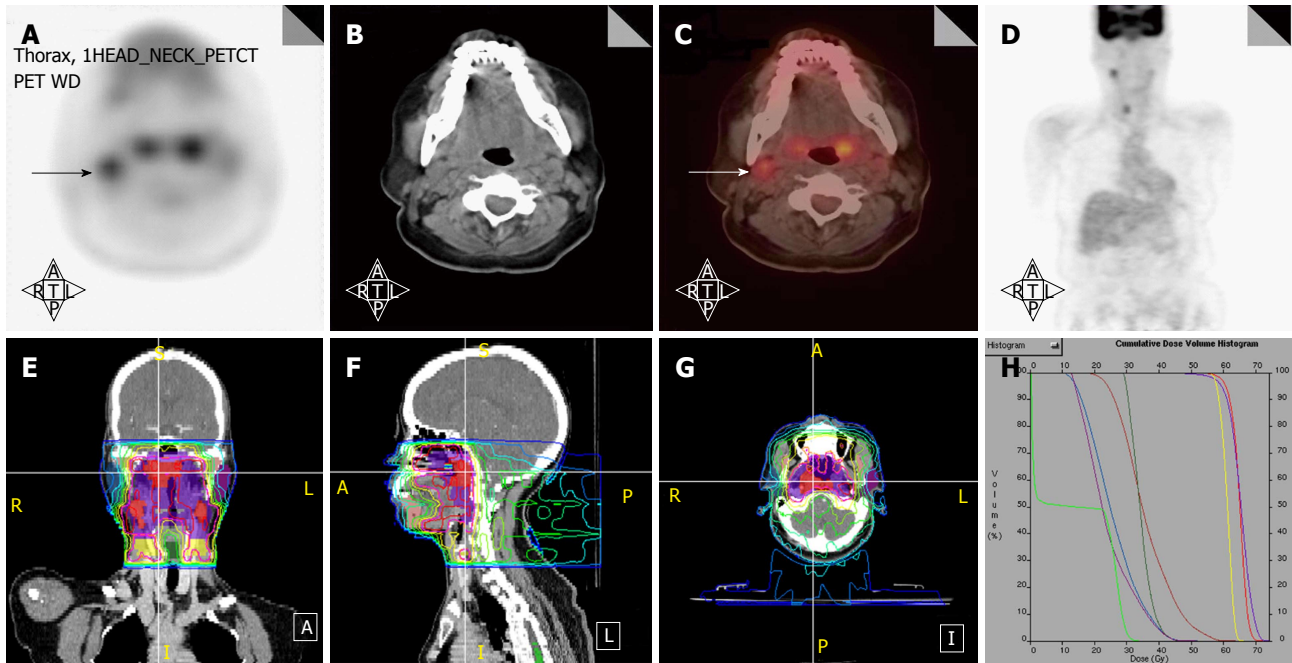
Positron emission tomography/computed tomography upstages a T1 nasopharyngeal cancer patient from N0 to N1. A-D: PET/CT images reveal that in addition to the T1 nasopharyngeal primary, there is increased FDG uptake in a level II node which was 1.0 cm in size (arrows). FNA of this node confirmed metastatic carcinoma. Thus, the patient was upstaged as T1N1 and treated with concurrent chemotherapy with IMRT; E-H: The IMRT plan for this patient treated the right level II node to a dose of 70 Gy. IMRT: Intensity modulated radiation therapy; PET/CT: Positron emission tomography/computed tomography; FDG: Fluorodeoxyglucose.
